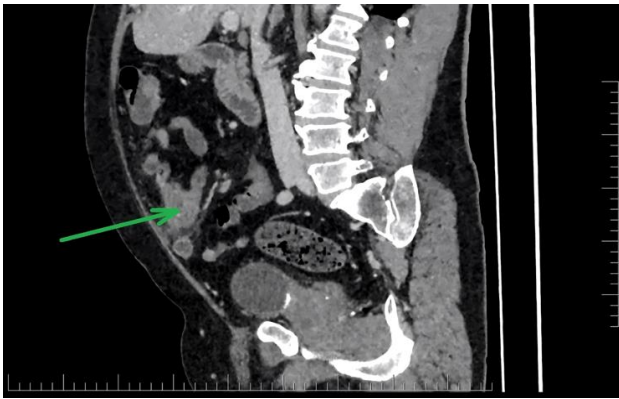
CT image in sagittal projection, MD infiltrate marked by an arrow (reprinted with permission of patient)
